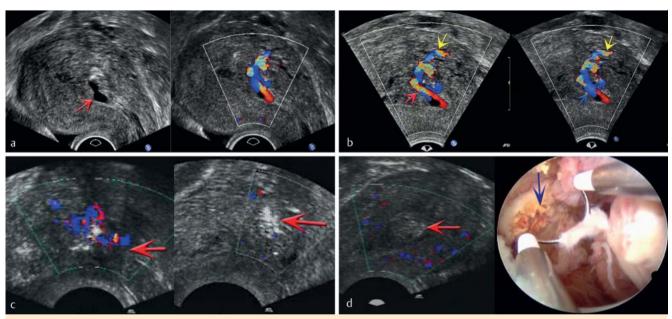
(Case 1) A 24-year-old patient, who had delivered her first baby by vaginal delivery a month ago, presented with massive menorrhagia, tachycardia (125 bpm), Hct 18% and Hb 5.2 g/dL and paleness. a Longitudinal section of the uterus depicting suspected retained products of conception with B-mode sonography showing a punched 15 × 8 mm anechoic space (red arrow) on the myometrial/endometrial border and in CDS a tangle of vessels with multidirectional turbulent high-velocity blood flow/low-resistance flow pattern. b Cross-section highlighting arterio (red arrow) and venous (blue arrow) elements of the lesion in the form of pulsations and the feeding vessel (yellow arrows) derived from a spiral artery. c Sonographically guided application of 2 ml of TISSEEL® Duo S Immuno to the feeding vessels by a 20 g needle (red arrow) producing a "flash-like" artifact in CDS. The turbulent flow immediately decreased after application producing a "snowstorm"-like pattern (red arrow). d Longitudinal section of the uterus 7 days after application revealing signs of retained products of conception (red arrow) without increased flow pattern on CDS. Removal of the retained products (blue arrow) on the posterior wall of the uterus is shown by hysteroscopy using a cutting loop.
